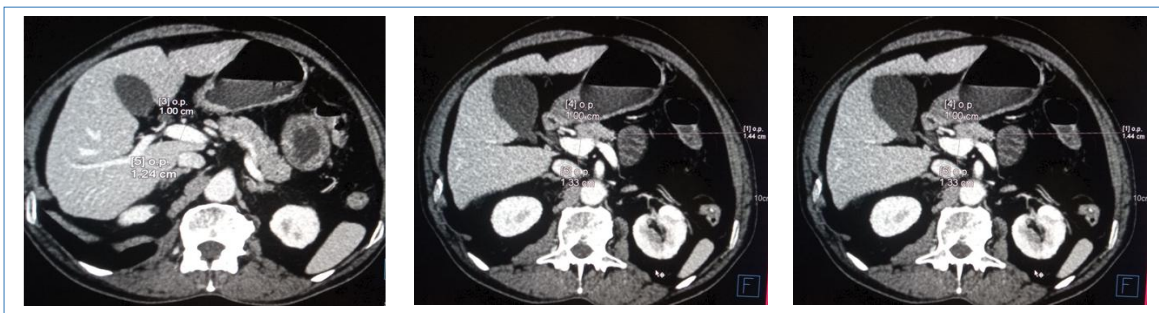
Reformatted axial CT image for MPVD measurement at 1 cm proximal to the branching of MPV (left), at 1 cm distal to the confluence of splenic vein and superior mesenteric vein (middle) and in between the branching and confluence of portal vein (right)
